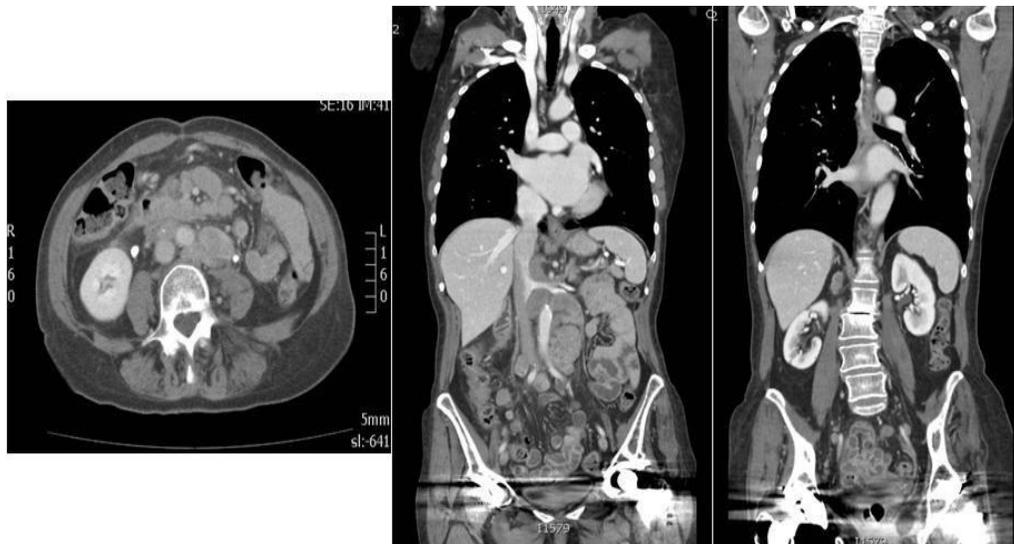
CT: Enlargement of the abdominal and pelvic lymph nodes.
